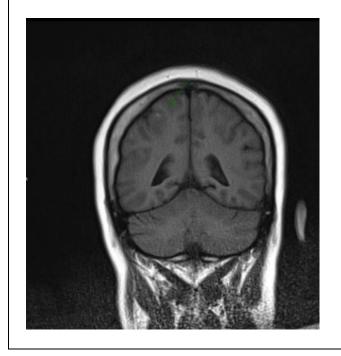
Brain MRI (coronal view) showing gyriform petechial high signal seen in the right posterior frontal/parietal region in the zone of acute infarct.
